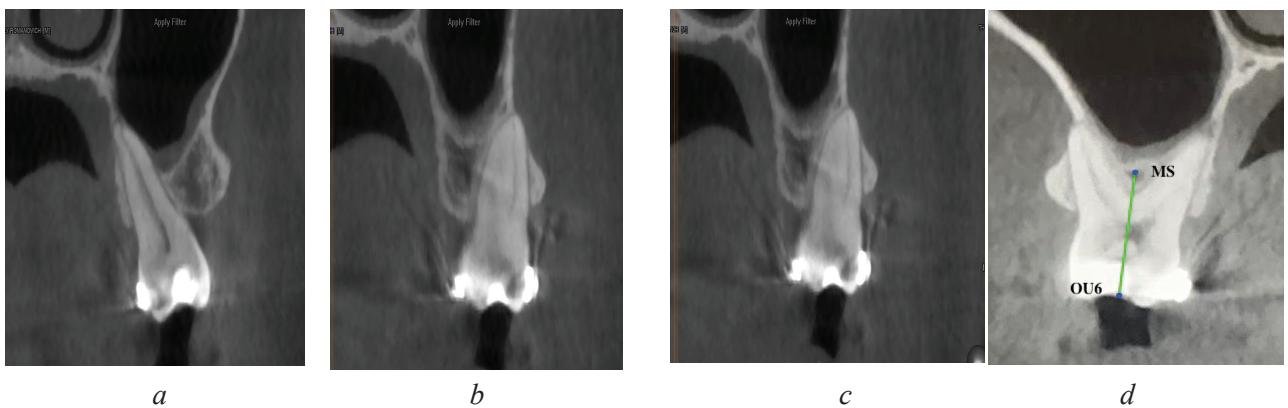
CBCT sections of the intruded tooth 2.6. a - palatal root. b - mesial buccal root. c - distal buccal root. d - tooth 1.6 after intrusion
